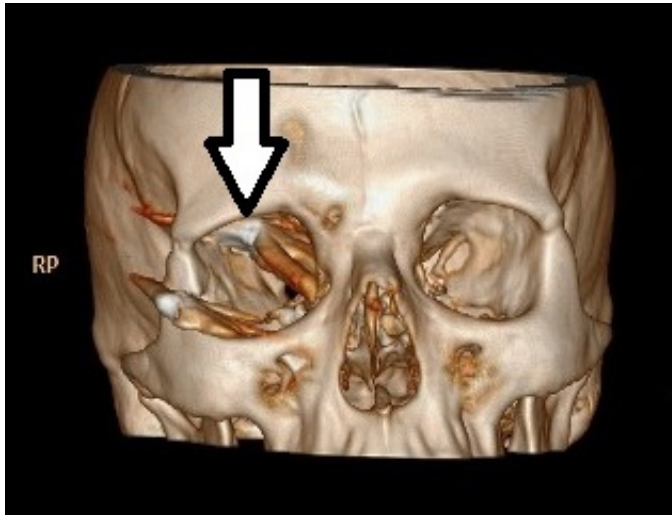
Three-dimensional orbital computed tomography of the patient. The arrow shows the bullet core (arrow)
